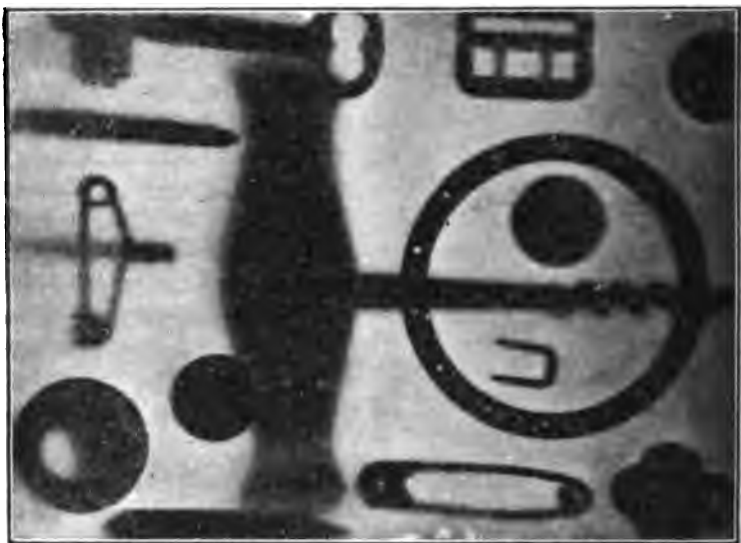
Radiograph taken with radium bromide, 10 milligrams; radioactivity, 300,000; distance from plate, 3 inches; time of exposure, 10 hours. Stanley plate used, which was covered by thick black paper, on which rested the objects here radiographed.
